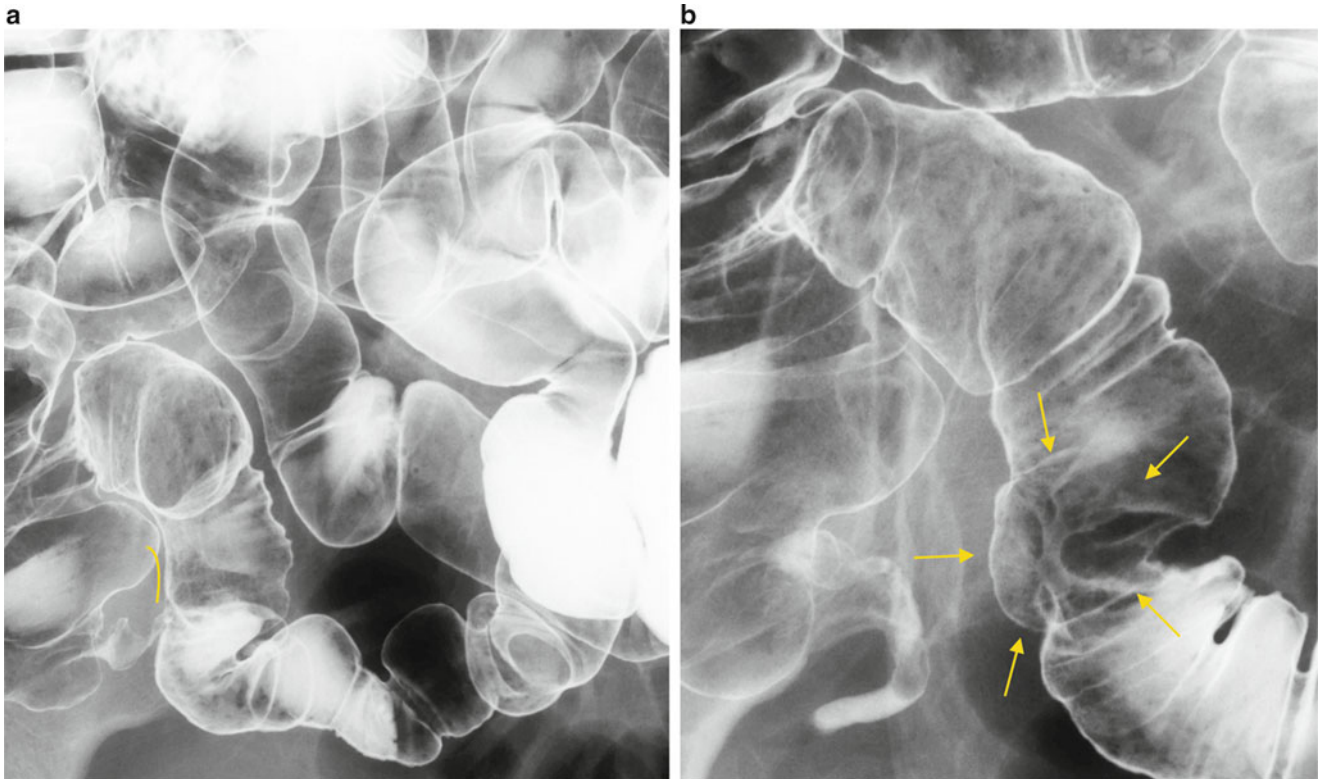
Double-contrast imaging in practice. (a) Double-contrast imaging focusing on the lower ileum. Barium is pooled in some areas, and there are overlapping loops of bowel. A lesion of the terminus of the ileum was originally suspected in this case, so radiography focused on that area, and a sclerotic area was noticed during scanning. (b) When
